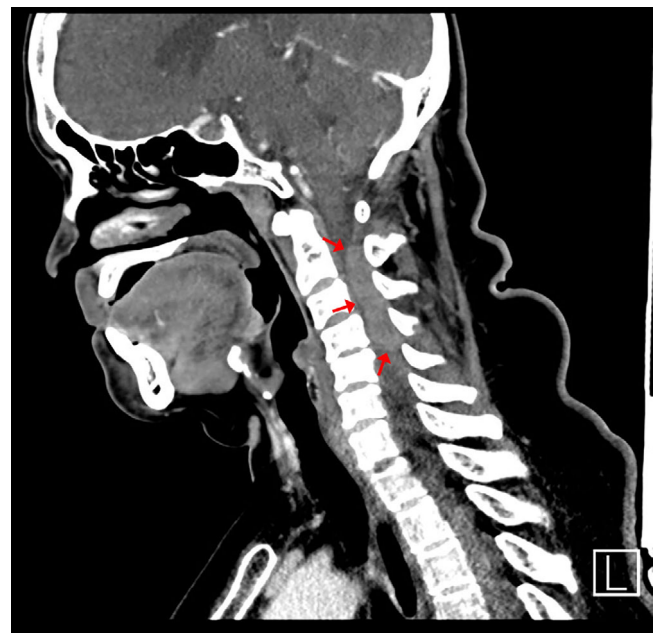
Sagittal view of computed tomography of cervical spine with contrast. Long hyperdense mass in posterior epidural space (red arrows)
